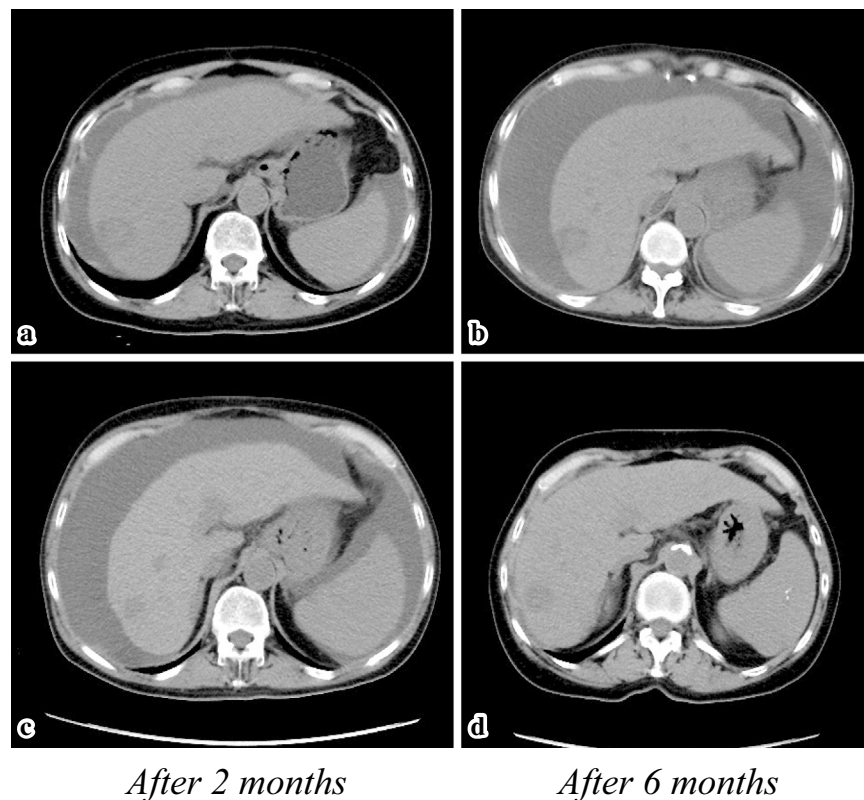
(a) Abdominal CT performed 2 months before TLV administration showed cirrhosis with massive ascites. (b) A comparison of the abdominal CT performed 2 months before TLV administration with that performed 1 month after TLV administration revealed an increase in ascites. (c) A comparison of abdominal CT performed 1 month after TLV administration with that performed 2 months after TLV administration showed no significant increase or decrease in ascites. (d) Abdominal CT performed 6 months after TLV administration showed a significant decrease in ascites.
